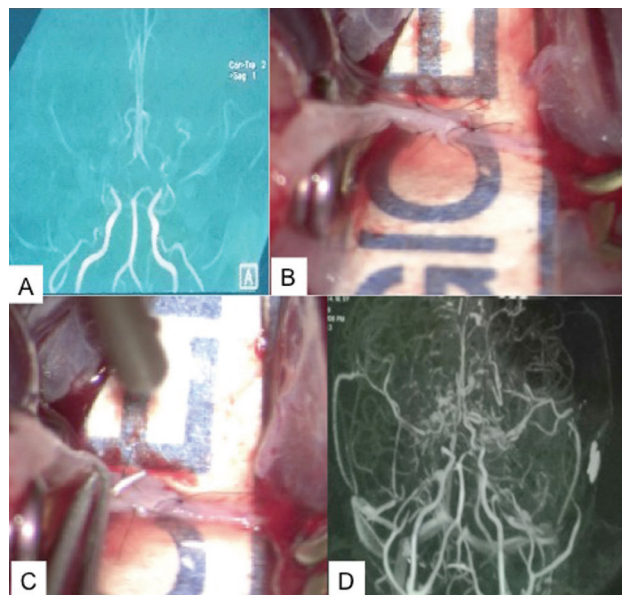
(A) preoperative MRA of the brain showing bilateral Moyamoya disease. (B & C) Preoperative picture of direct STA-MCA bypass. (D) Postoperative CTA on the 1st POD showing patent STA-MCA anastomosis with increased vascularity.
